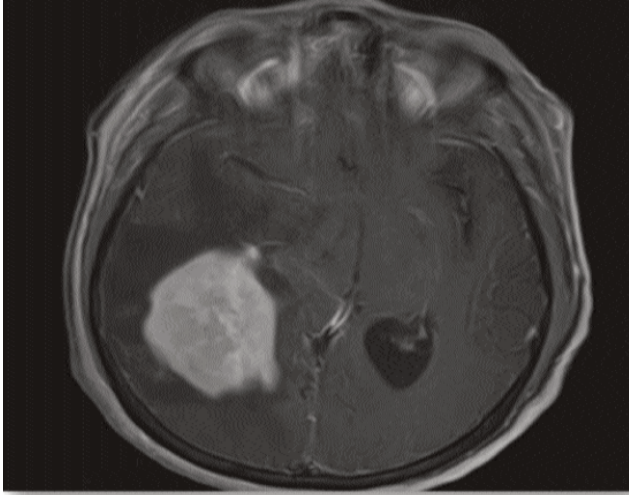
MRI brain T1WI with gadolinium enhancement showing large enhancing abnormal signal intensity lesion in the right occipital lobe involving part of splenium of corpus callosum and wrapping the right occipital horn. Later, neuronavigation guided stereotactic biopsy proved PCNSL.
